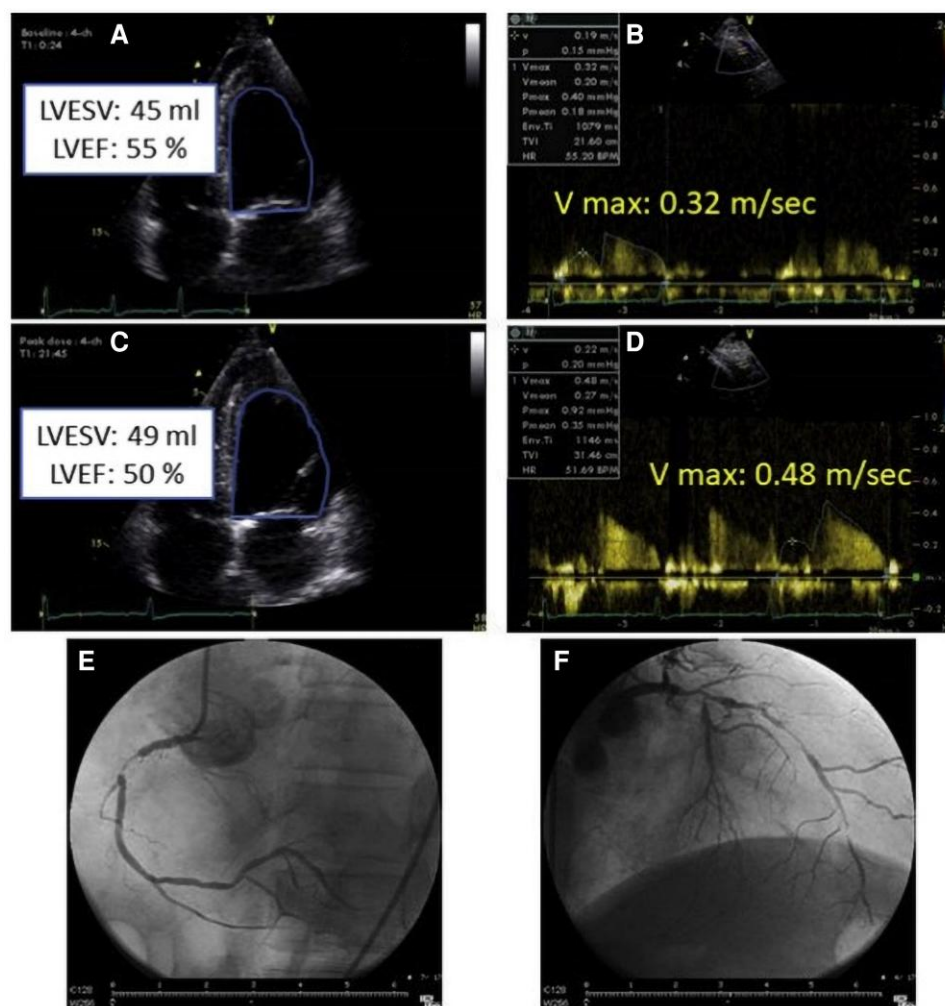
A 68-year-old woman with Hodgkin lymphoma localized in the mediastinum, treated with 12 cycles of doxorubicin, bleomycin, vinblastine, and dacarbazine and radiotherapy, referred with effort chest pain for dipyridamole stress echocardiography. (A) Resting four-chamber view showed preserved left ventricular (LV) ejection fraction and no wall motion abnormalities. (B) Resting coronary flow in the distal left anterior descending coronary artery (LAD) was 0.32 m/s. (C) Peak-stress four-chamber view showing LV systolic enlargement and diffuse wall motion abnormalities. (D) Peak coronary flow in the distal LAD was 0.48 m/s, and coronary flow reserve was 1.5. (E, F) Coronary angiography showed multivessel disease with critical obstruction of the three main vessels.
